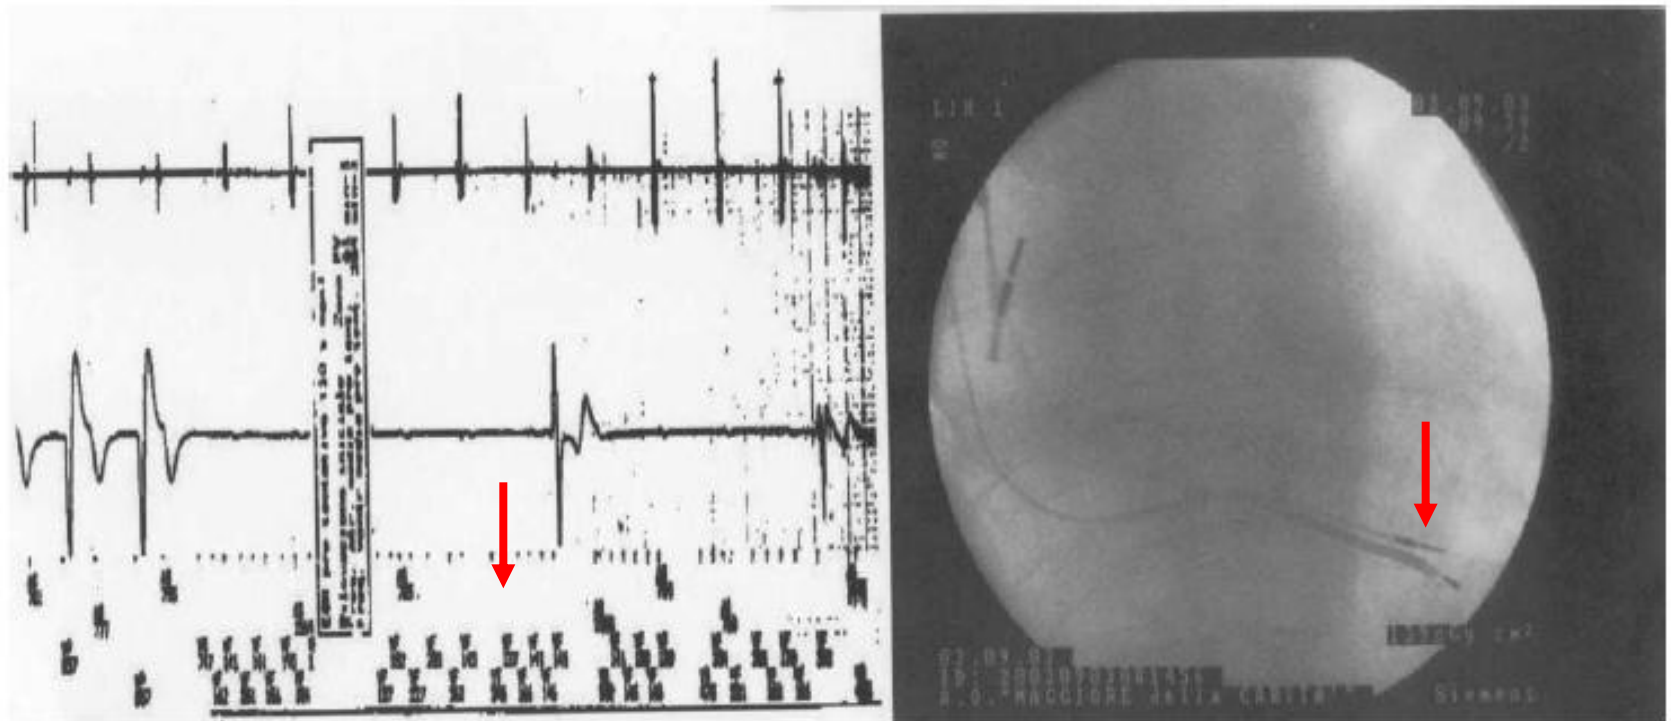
Patient with a dual-chamber ICD, complete AV block, and paroxysmal atrial fibrillation. Stored atrial (first line) and ventricular (second line) intracardiac electrograms reveal an inappropriate shock because of oversensing of myopotential signals. Myopotential sensing inhibited ventricular pacing and caused an inappropriate 'VF' detection, with consequent ICD discharge (left panel). Erroneous therapy delivery persisted after ventricular sensitivity reprogramming; an additional pacing/sensing lead was fixed in the low interventricular septum (chest X-ray at right panel).
